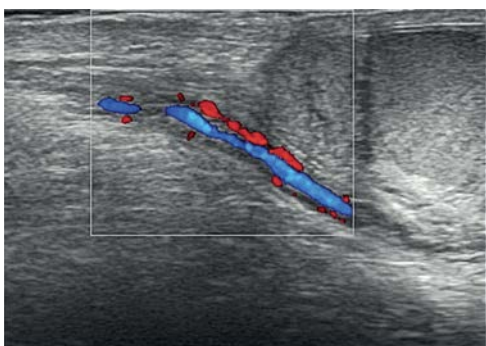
Triplex ultrasound evaluation of testicular vessels: right testicle after reduction (A); intact left testicle (B)
